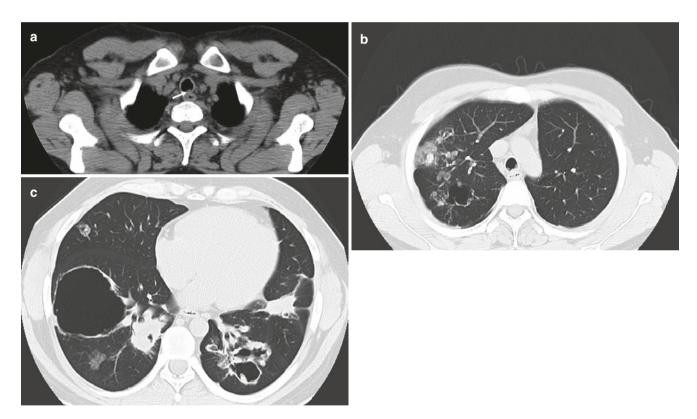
25-year-old man with recurrent laryngeal and pulmonary papillomatosis. (a). Axial CT image shows small nodule (arrow) projecting in the lumen of the trachea. (b, c) Axial CT images with lung
